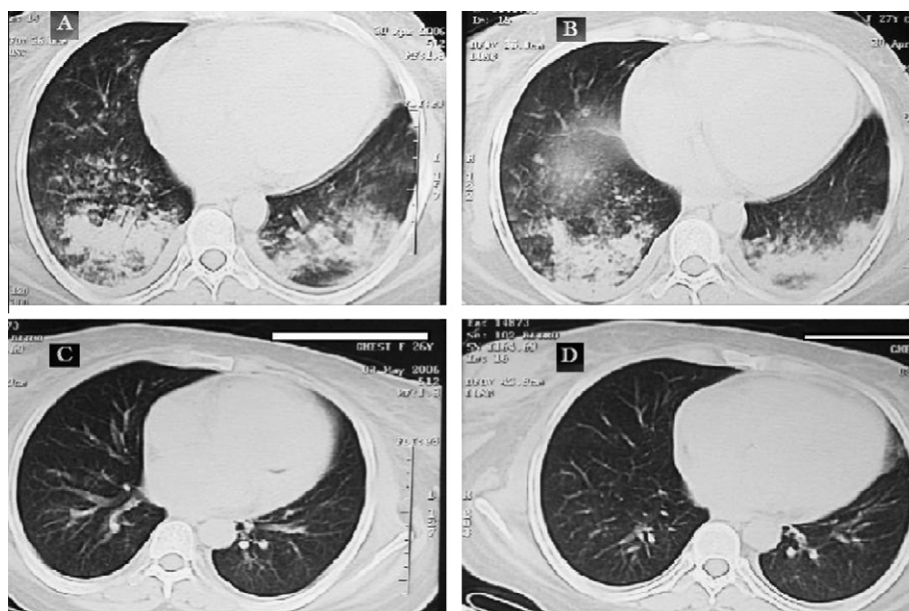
HRCT chest of case no. 5. (A and B) Area of hyperdensity on both lung fields (suggestive of hemorrhage) at the 1st day of attack. (C and D) Complete resolution of both lungs on the 4th day of attack following 3 days dose of pulse steroid therapy (1 g/day).
